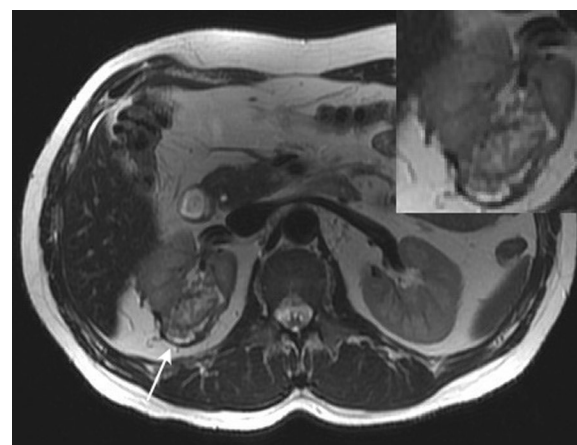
Follow-up MRI at 3 months. Axial T2WI sequences highlighting a hypointense rim (arrow) in the posterior–superior aspect of the right perirenal space, most likely indicating benign fibrotic tissue
